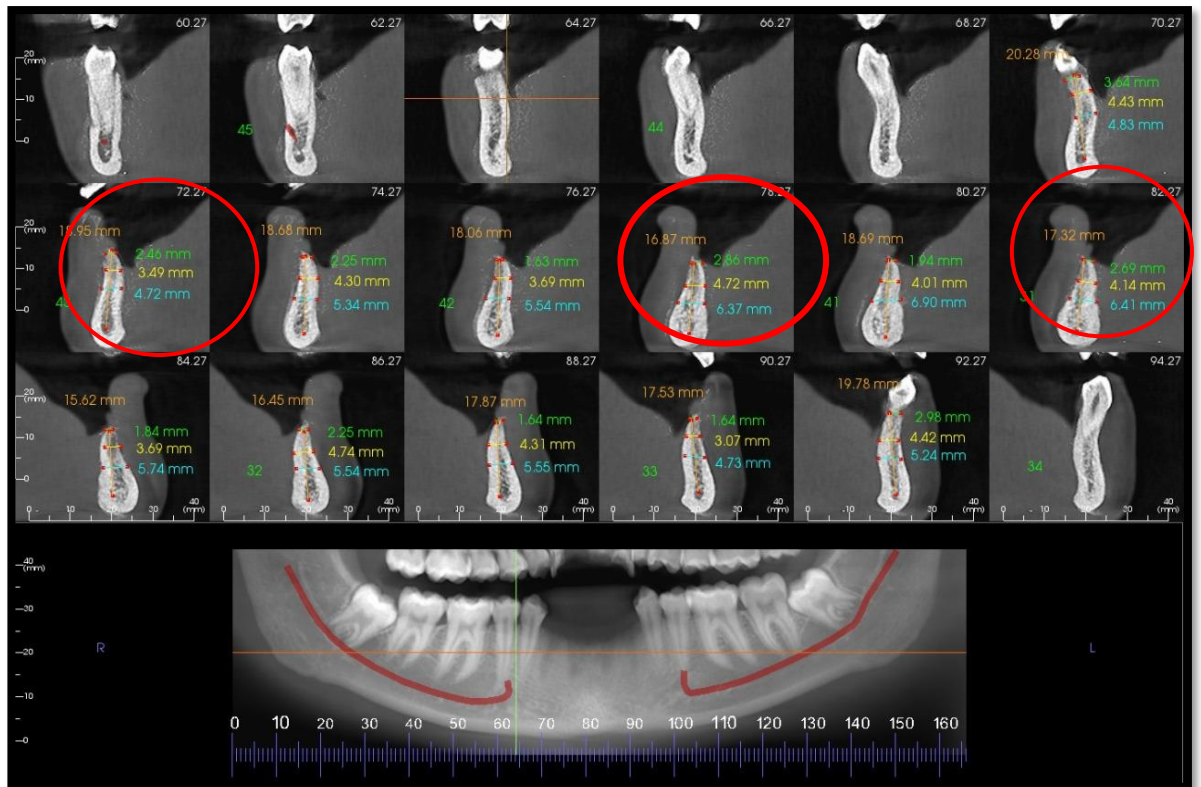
CBCT - coronal view
